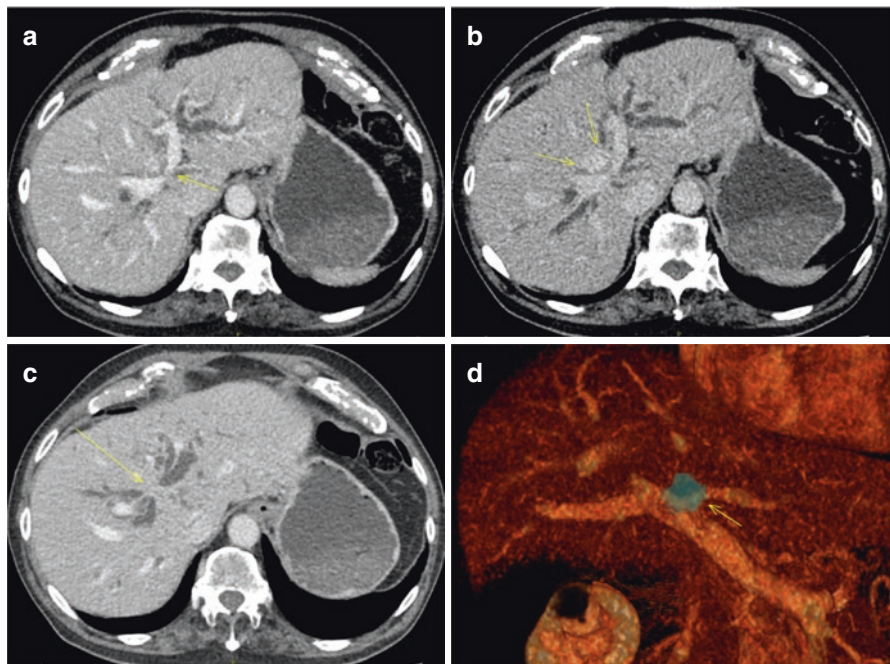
CT of a patient with a central cholangiocarcinoma. (a) Infiltration causing narrowing of the left portal vein (arrow). (b) Late enhancement of the tumor (arrows). (c) Lesion causing obstruction of the main bile ducts (arrow). (d) 3D reconstruction showing the relation of the tumor with the portal vein
